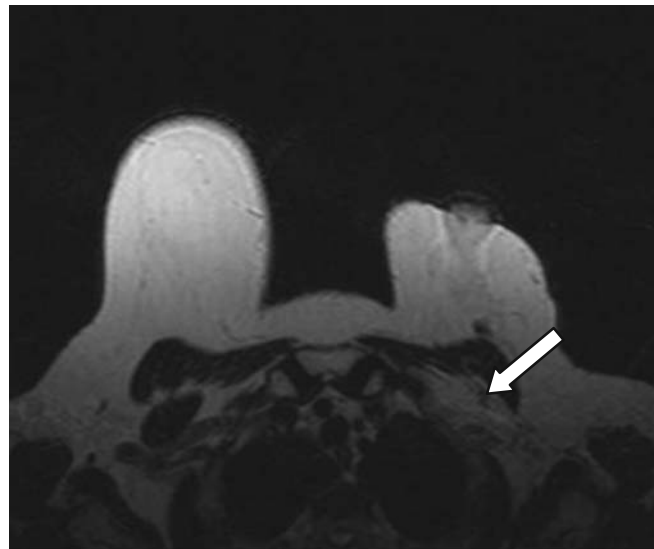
Case number 3313 of April 25th, 2005; 56 year-old patient, left radical mastectomy in 2003, reconstruction with TRAM flap after 6 months; T2-weighted sequence in the transverse plan showing the absence of the left pectoralis minor muscle (white arrow).
